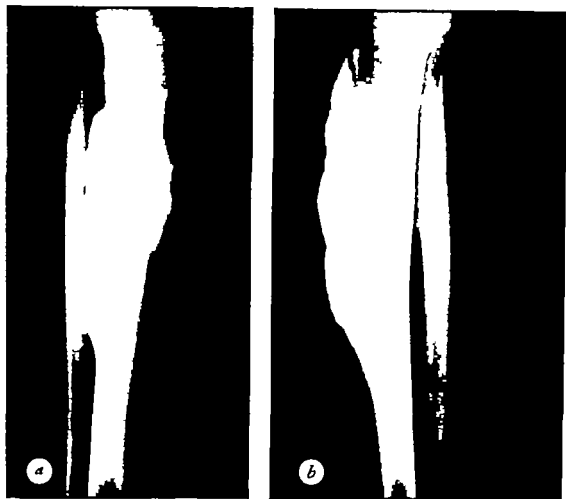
a* and *b* Anteroposterior and lateral views of a dense parosteal osteoma of the tibia of a 45-year-old man who had noted gradually increasing swelling for 31 years. This tumor bears roentgenographic resemblance to parosteal osteogenic sarcoma.
